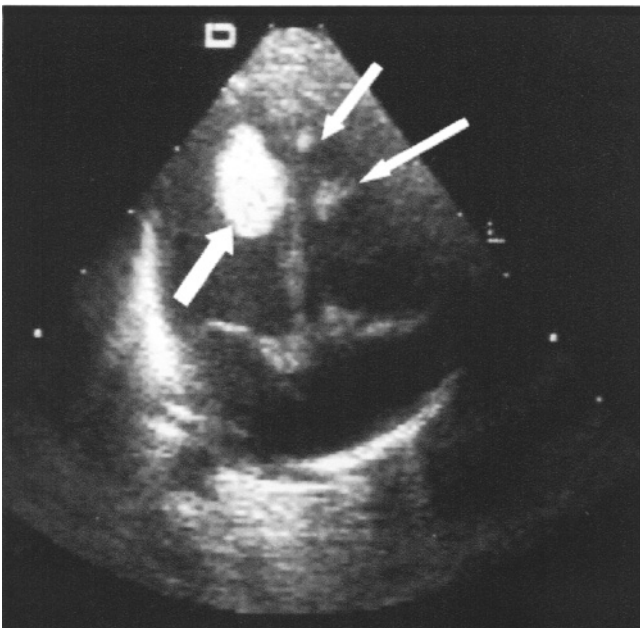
Ultrasonic demonstration of multiple cardiac rhabdomyomas (arrows). Reproduced with permission from Roach ES, Delgado MR: Tuberous sclerosis. *Dermatol Clin* 1995;13:151-161.
